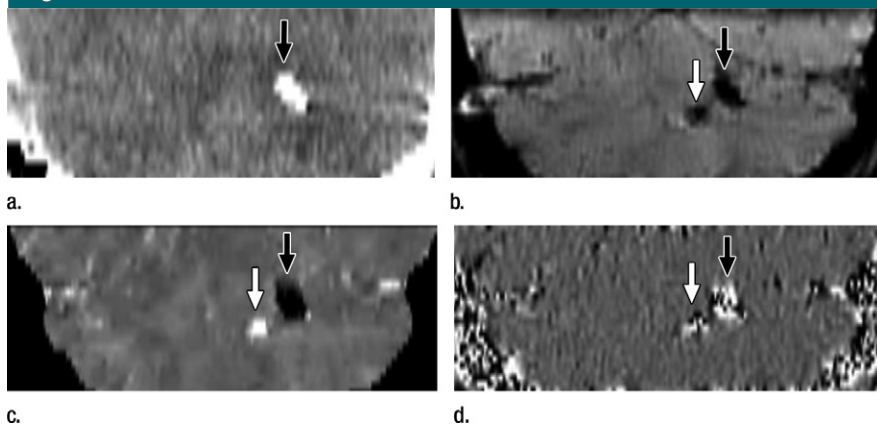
Calcification and hemorrhage outside deep brain nuclei in 10-year-old girl with vascular disease. Images are reformatted in coronal plane. (a) CT scan shows only hyperattenuating calcified lesion (arrow) (maximum CT number = 742 HU). (b) T2*-weighted MR image shows two hypointense lesions (arrows), one of which corresponds to calcification on a. (c) QSM image distinctly shows a diamagnetic lesion (black arrow), which corresponds to calcified lesion on a, and a paramagnetic lesion (hemorrhage, white arrow). (d) GRE phase image shows the two lesions (arrows) with heterogeneous appearances, which caused readers 3 and 4 to misclassify calcified lesion as hemorrhage.
